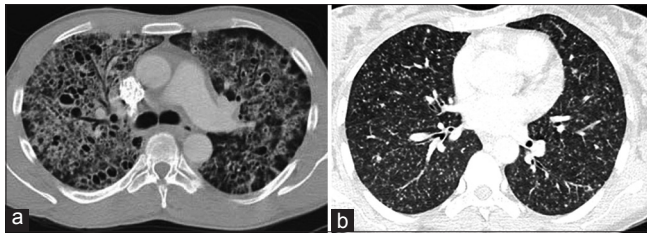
(a) Axial HRCT image reveals ground glass attenuation with crazy paving pattern and multiple cysts in bilateral lung fields which is classic of *Pneumocystis carinii* pneumonia. (b) HRCT image reveals miliary tuberculosis in bilateral lung fields in a different case
